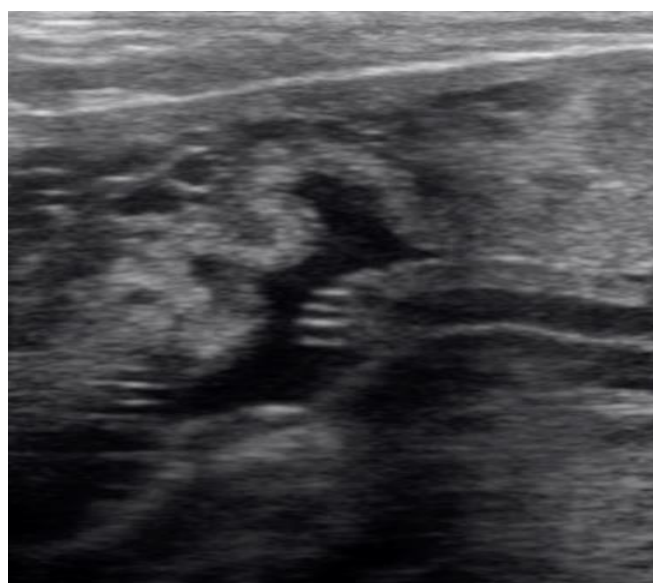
Ultrasonographic image of pregnant uterus
